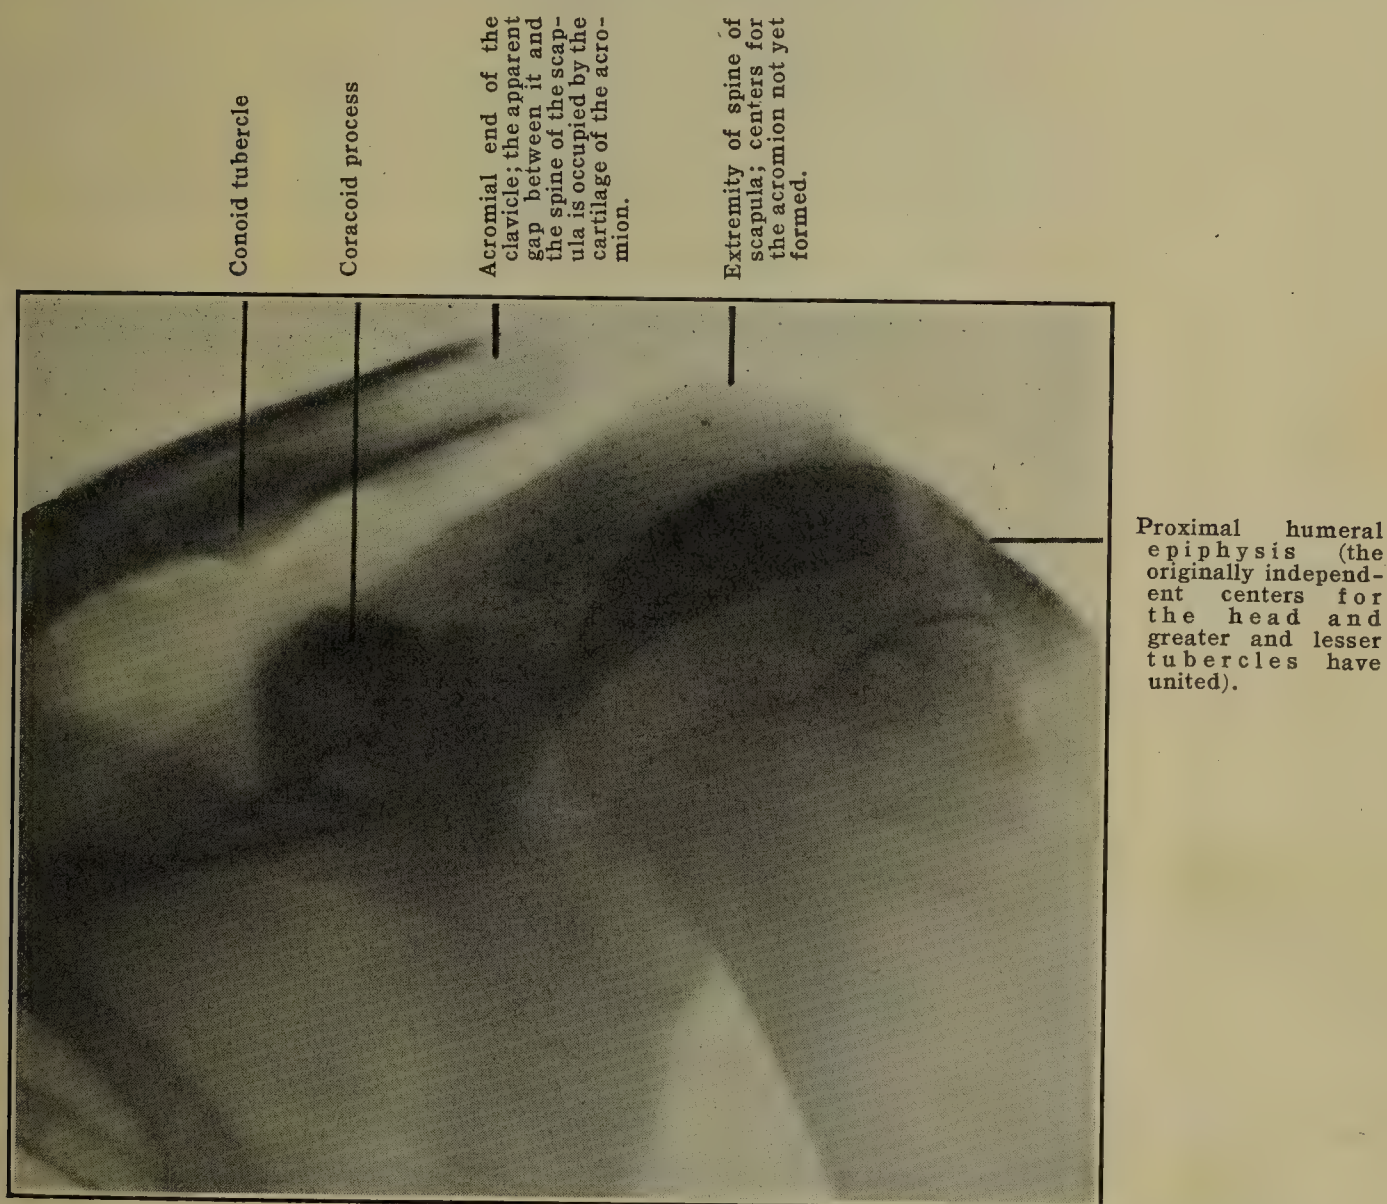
SHOULDER OF A BOY OF SIXTEEN YEARS. From an X-ray plate by Dr. Sherwood Moore, Washington University. (Cf. adult, fig. 220.)
